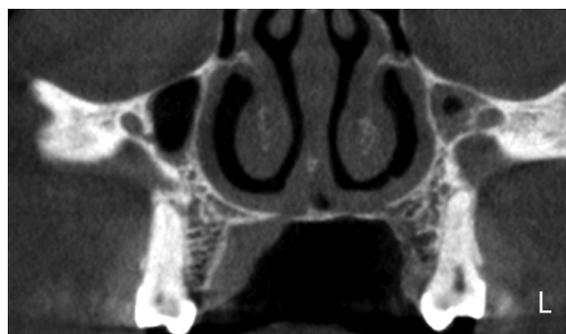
Cone beam computed tomography. Coronal bony window at the level of the premolars. Bony erosion and the loss of the cortex on the palatal aspect of the alveolar ridge are visible on the left.
